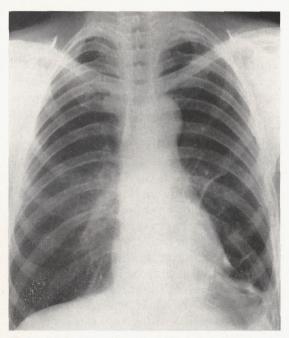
Roentgenogram of chest made approximately 2 weeks after operation revealing absence of right mediastinal shadow representing aneurysm which was present in preoperative film shown in Figure 1.
